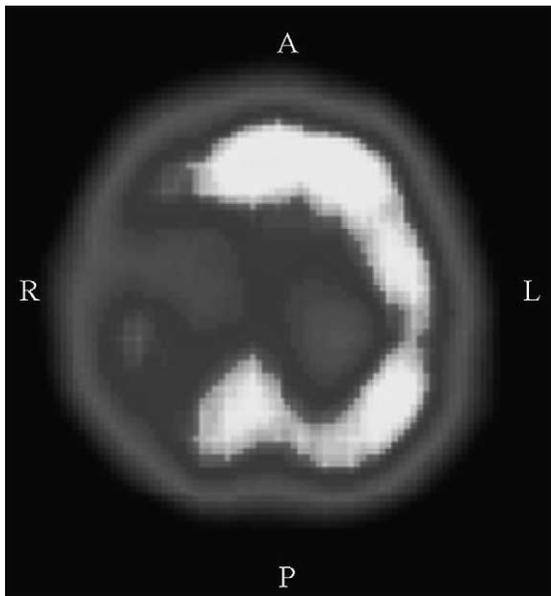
^{99m}Tc -ECD cerebral SPECT shows frontal, parietal and temporal cortical right hypoperfusion.
